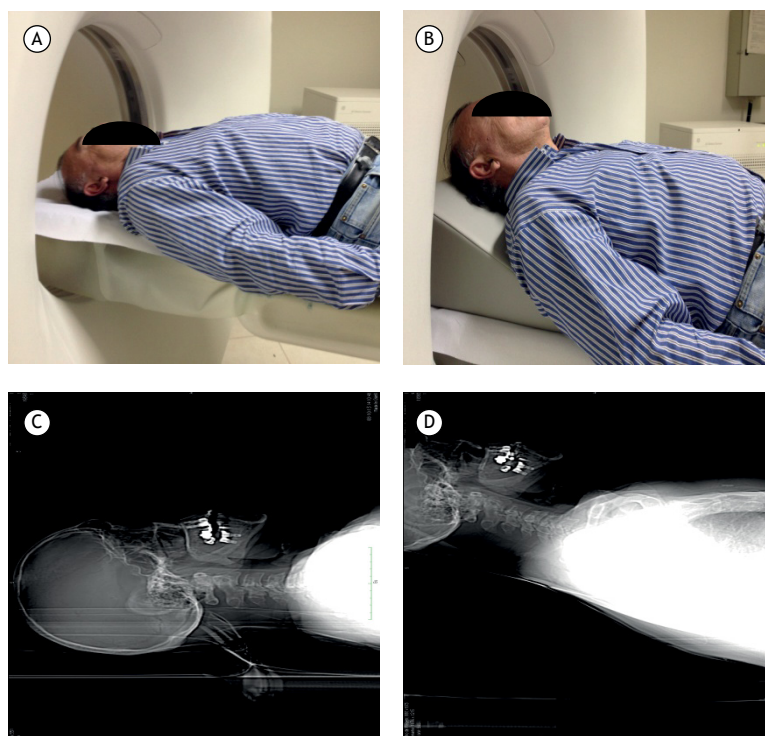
Patient without head elevation (neutral position; in A) and with head elevation by a 44° wedge (in B). CT scans obtained with the head in the neutral position (in C) and elevated by 44° (in D).
